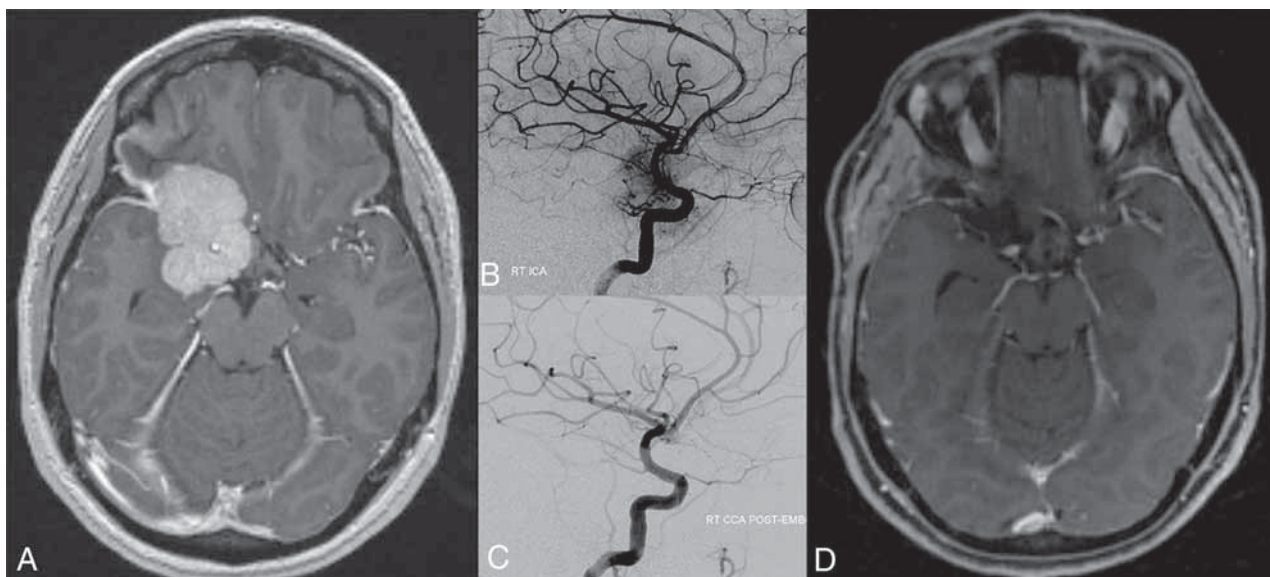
A patient with a large right sphenoid wing meningioma with encasement of the ICA visible on a T1-weighted, axial, postcontrast image (A). Right ICA DSA injection in a lateral view (B) demonstrates the supply to the tumor from an enlarged meningohypophyseal trunk. After selective embolization through both the meningohypophyseal trunk and indirectly from the middle meningeal artery, a final right common carotid artery injection in a lateral view (C) demonstrates interval 90% tumor embolization. Complete gross resection of the meningioma is visible on the T1-weighted, axial, postcontrast image (D). RT indicates right; CCA, common carotid artery; EMB, embolization.
